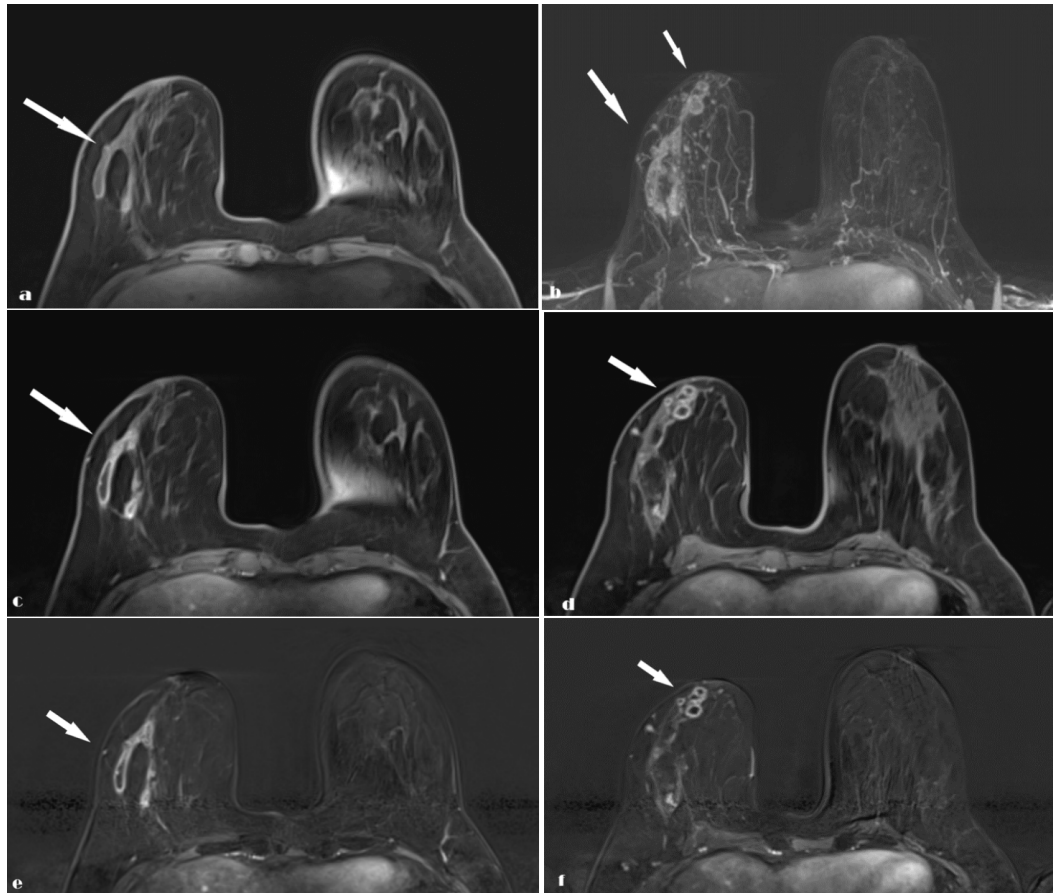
Breast MRI findings in multicentric right breast abscess. (a) Axial T1-weighted image demonstrating a predominantly hypointense lesion in the right breast (arrow), consistent with a fluid-containing collection. (b, c) Axial T2-weighted SPAIR images showing multiple hyperintense multicentric lesions with heterogeneous internal signal, corresponding to proteinaceous or purulent fluid content, with surrounding parenchymal edema. (d) Axial T2-weighted SPAIR image demonstrating a reactive lymph node in the right axilla, with preserved morphology and signal characteristics.
